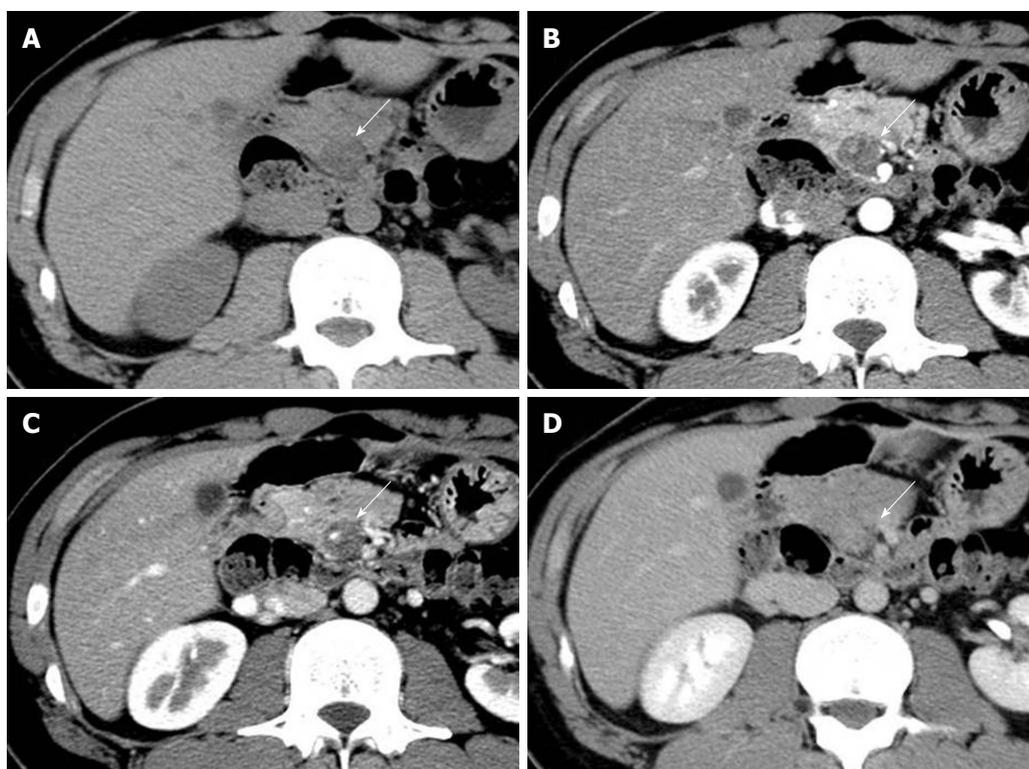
In Case 1, computed tomography indicated a round tumor (arrows) near the head of the pancreas. Gradually increasing enhancement of the tumor was shown by a dynamic computed tomography study. A: Plain; B: Early phase; C: Portal phase; D: Delayed phase.
